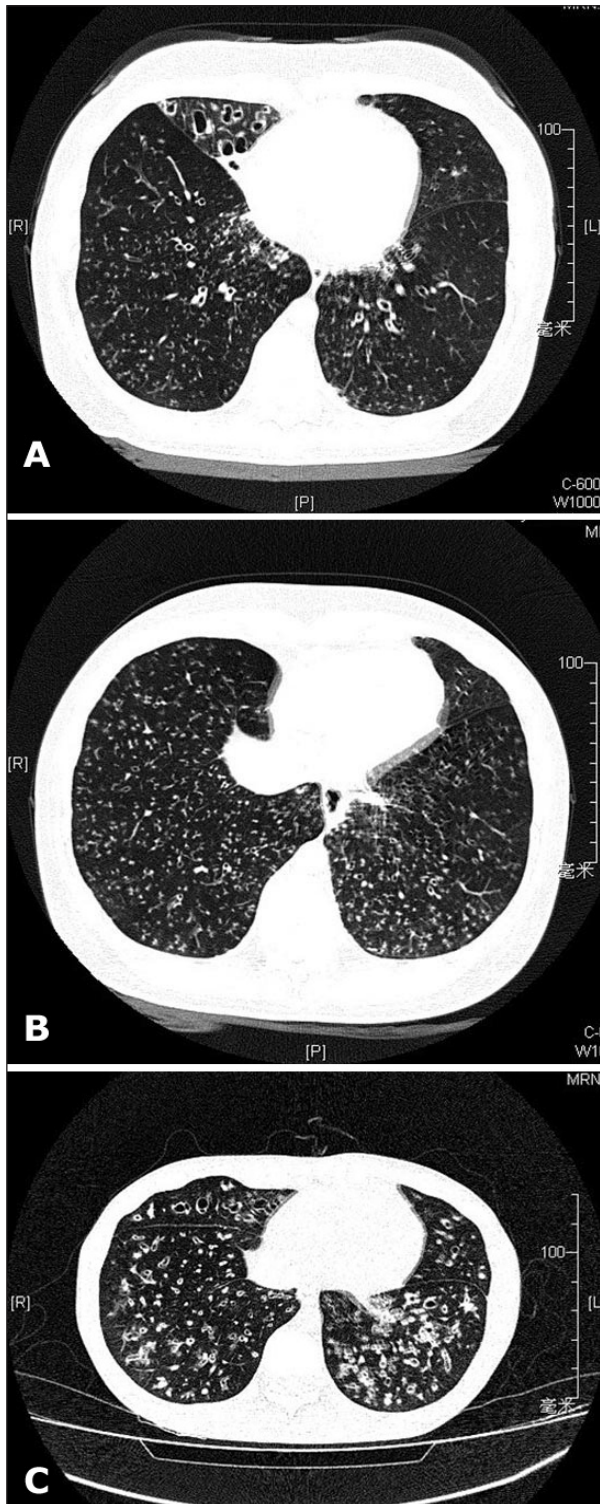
HRCT showed bronchiectasis and bronchiolitis, ring-shaped or ductal opacities in upper, middle, and lower lungs, some of these changes were accompanied by small nodules. bronchiectasis were seen in right middle lobe and left lingular lobe.
